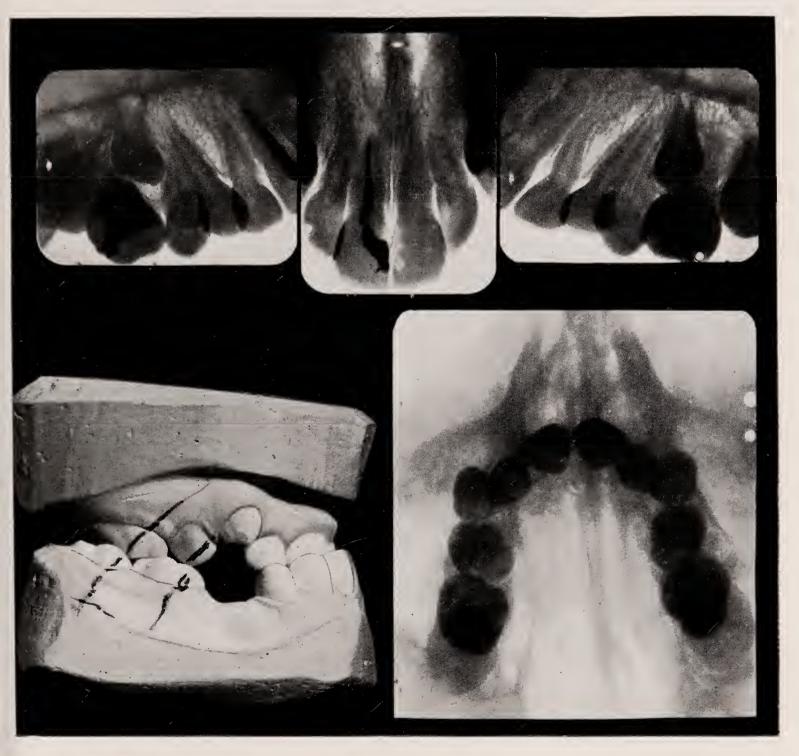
Unsuspected apical infection of incisor about to undergo orthodontic treatment. Occlusal radiograph shows position of impacted premolars.
